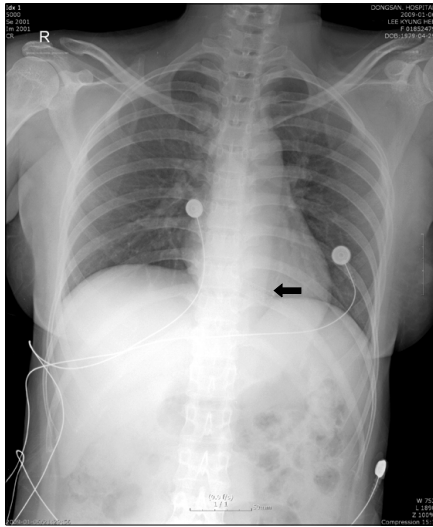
Chest radiograph showed that the displaced stent (arrow) had migrated into the right ventricle.
